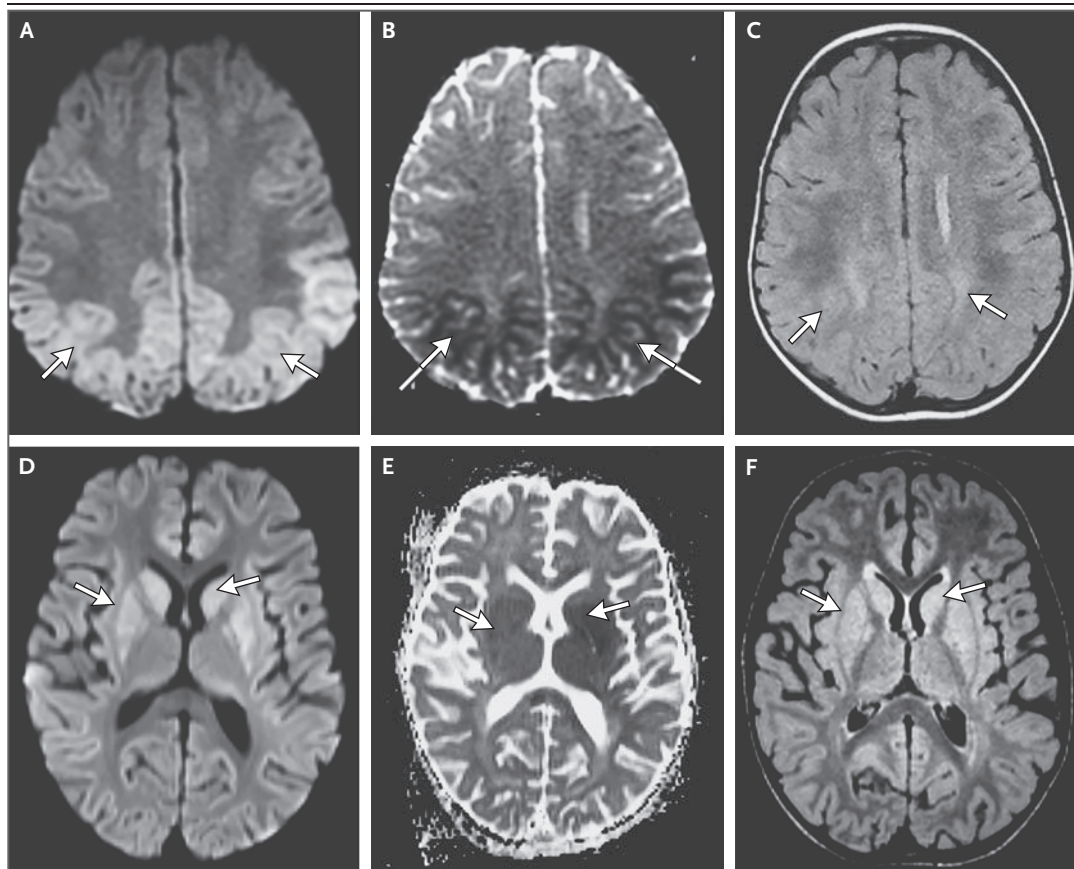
MRI of the Head.
